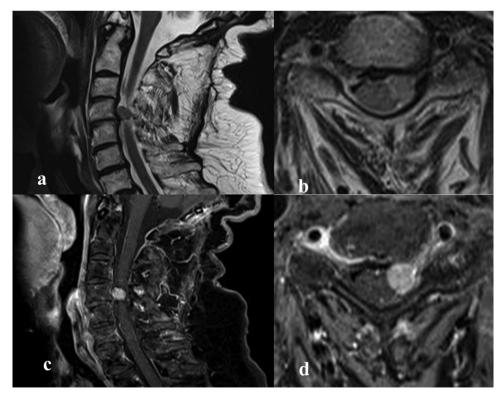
Sagittal T2WI (a) and axial (b), Sagittal T1WI with contrast medium (c) and axial (d) cervical spine MR images. The mass was in the C4-C5 intradural extramedullary space. The mass showed an iso-signal on T2WI (a, b) and homogeneous enhancement with contrast medium on T1WI (c, d).
